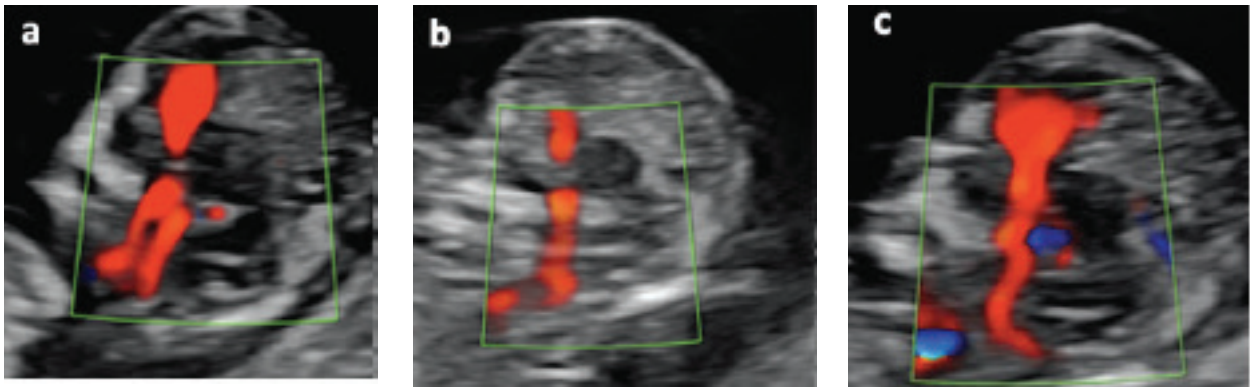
Approach to imaging of the basilar artery (BA) on color Doppler a) Incorrect plane; the internal carotid artery (ICA) is also seen in this plane anterior to the BA. Proximally, the anterior cerebral artery (ACA) is also seen, b) Suboptimal plane which shows the course of BA and a part of ACA. This plane is suboptimal because the borders of brainstem are not clear, c) The ideal plane which shows the BA, ACA, and the anterior and posterior borders of the brainstem. The BA was identified optimally in this correct midsagittal plane where ICA was not visualized. Measurements were obtained at the anterior line of the brainstem
